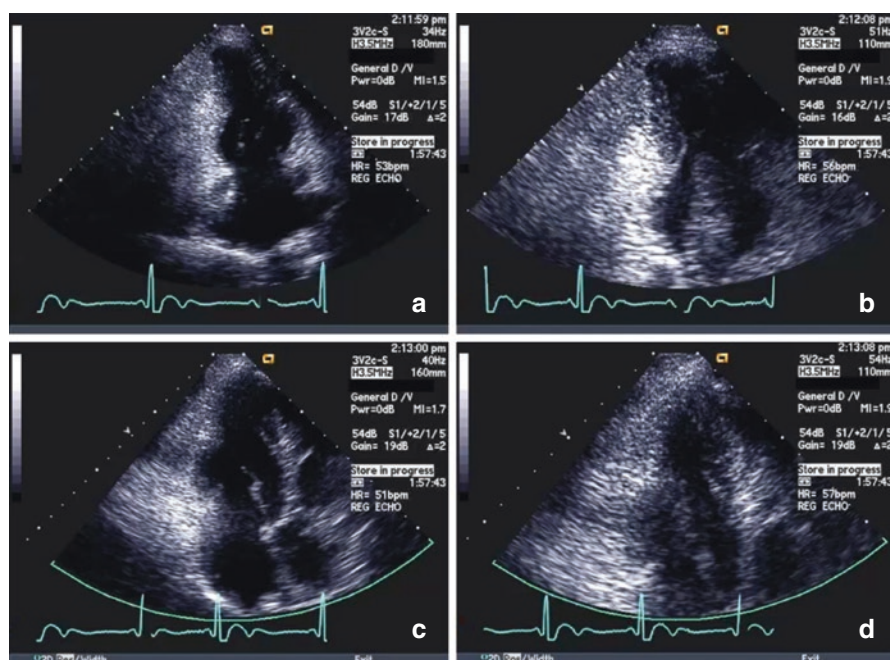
Apical two-chamber (a and b) view showing enlarged LA but poor visualization of wall motion of the apical, mid-inferior and apical, mid-anterior segments. Apical long-axis view (c and d) with poor visualization of the apical lateral segment and the mid-antero-septum and the true apex. (LA left atrium)
